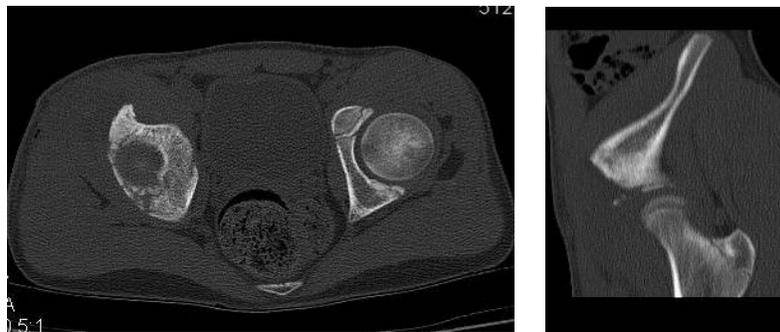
Axial and sagittal CT scans showing the excision spot and the local bony anatomy after the surgery
